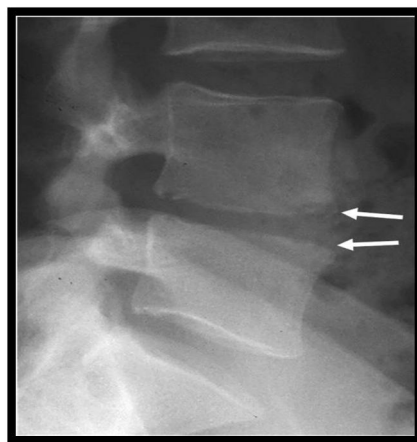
Early tuberculous spondylodiscitis. Lateral lumbar spine radiograph shows subchondral bone resorption of inferior L4 and superior L5 vertebral body corners (white arrows), with L4-L5 disc narrowing[40].
